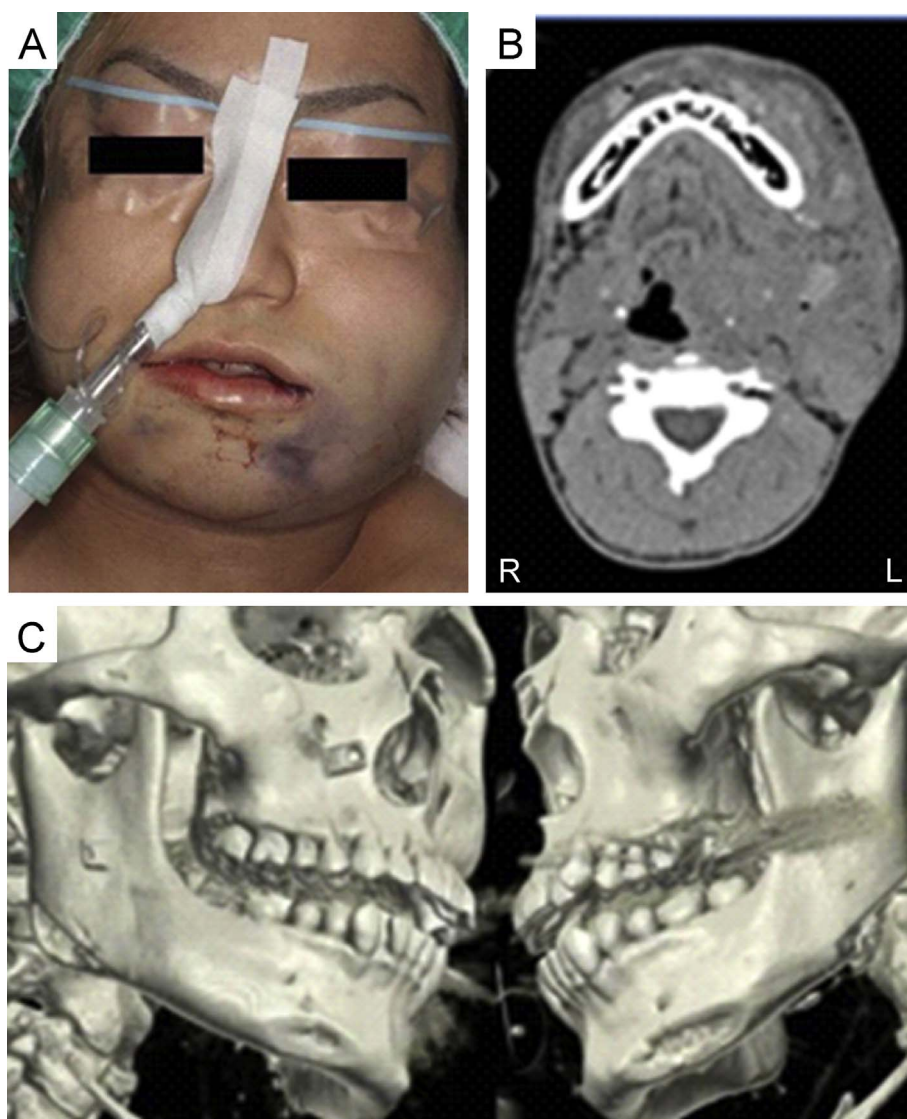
Findings before haemostasis. A. Marked bilateral facial swelling was present. B. Horizontal computed tomography (CT) image showing internal swelling, predominantly on the left side. The respiratory tract shifted to the right owing to severe swelling. C. Three-dimensional CT image showing evidence of bilateral mandibular angle and plane osteotomy.
